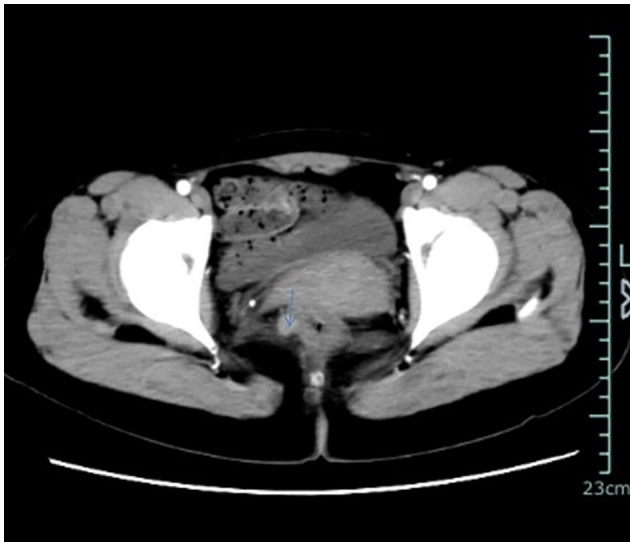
At 6 months after the initial surgery, pelvic enhanced CT indicated metastatic lesions in the perirectal fat space (arrow).
